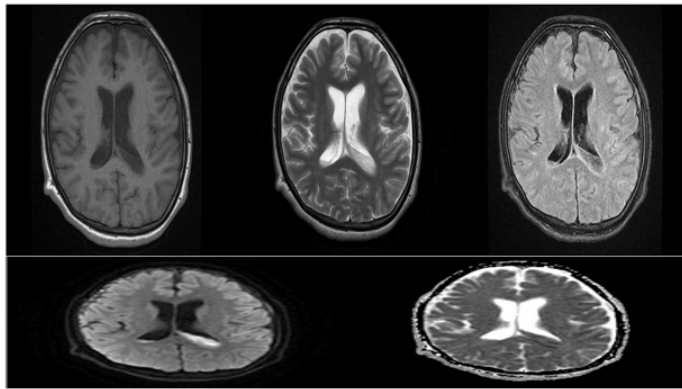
Simple brain magnetic resonance, axial T1, T2, FLAIR sequences, diffusion weighted imaging and Apparent Diffusion Coefficient (ADC): show an altered signal of intraventricular fluid, especially in FLAIR sequence.
